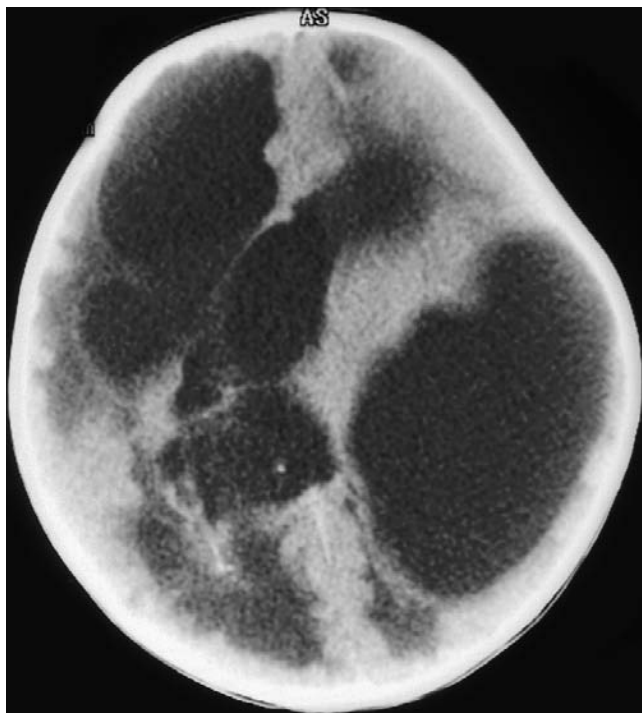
CT ventriculogram depicting multiloculated hydrocephalus.
